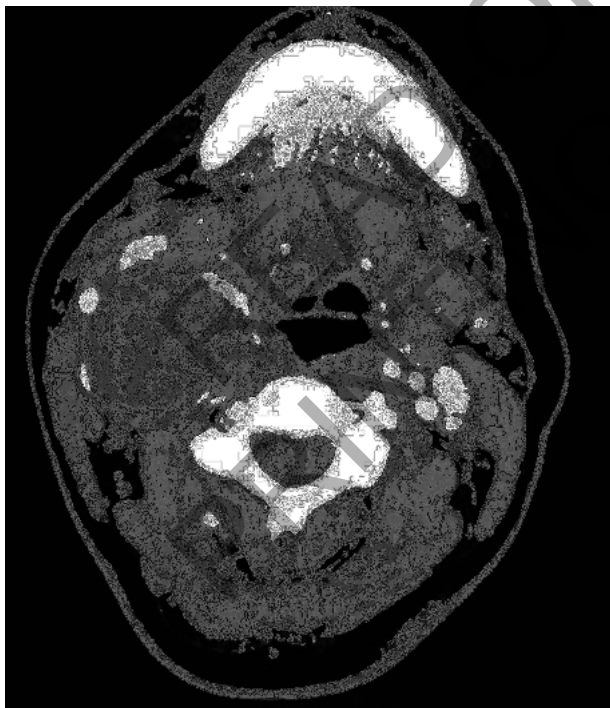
Contrast-enhanced CT scan.
